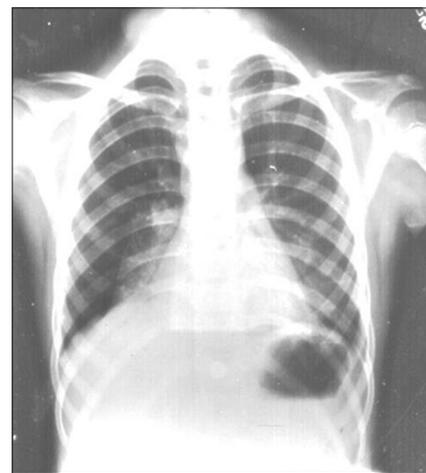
Chest X-ray of Case number 3.
